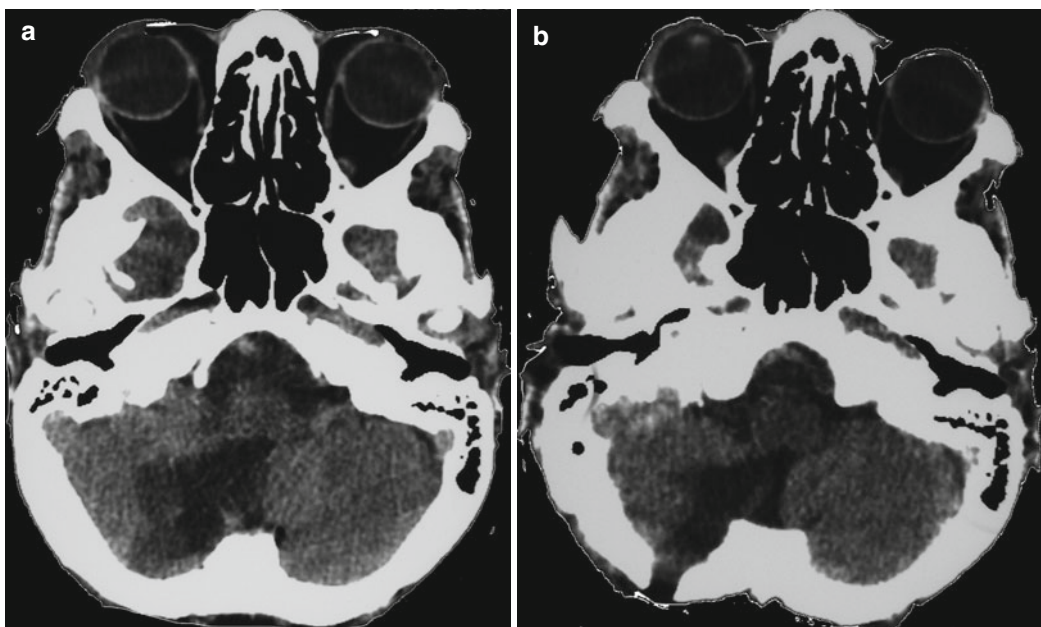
(a, b) Postop CT control showing bone opening and bulbar decompression after endoscopic aspiration of ischemic tissue. Bimanual microsurgical technique was ensured
